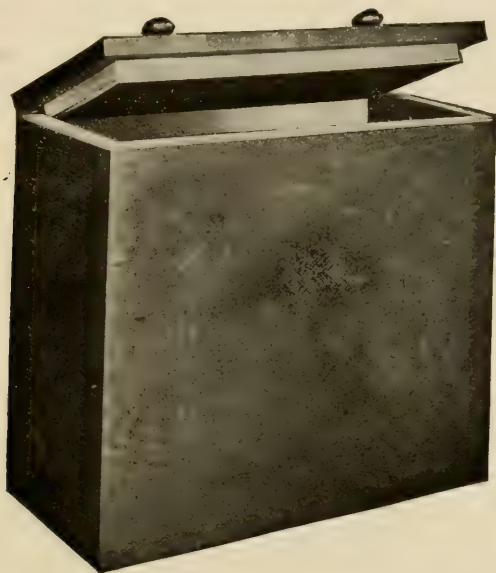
Lead-lined, X-ray-proof box for photographic supplies.
